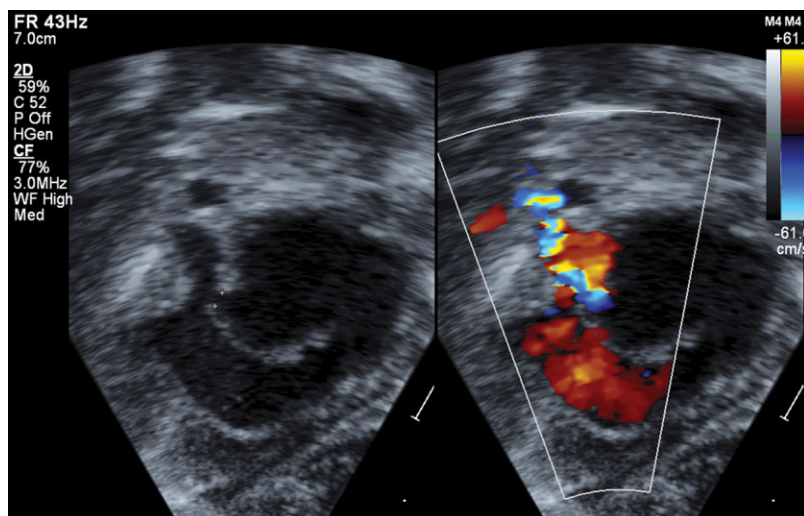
Transthoracic 2D echo with and without color flow mapping documenting a thin intraatrial septum (1.2 mm) and a restrictive superiorly located atrial septal defect (mean gradient at least 13 mm Hg) with left to right flow.
